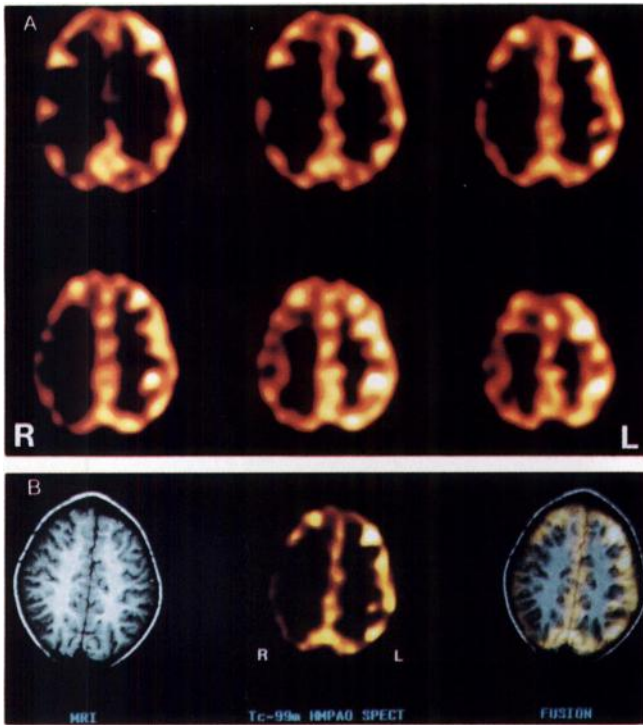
(A) Six sequential ^{99m}Tc -HMPAO brain SPECT scan sections from Patient 1 show low and asymmetric right parietal and right posterior frontal tracer uptake (CM + 7.5 cm; regions 7–11). (B) Coregistered MR, SPECT and fusion image at section level CM + 7.5 cm. The MRI section (left) is normal. The coregistered ^{99m}Tc -HMPAO brain SPECT scan section (middle) shows low and asymmetric tracer uptake by the parietal and posterior frontal lobes, right lower than left, with no corresponding anatomic abnormality, as demonstrated by the MRI-SPECT fusion image (right).
